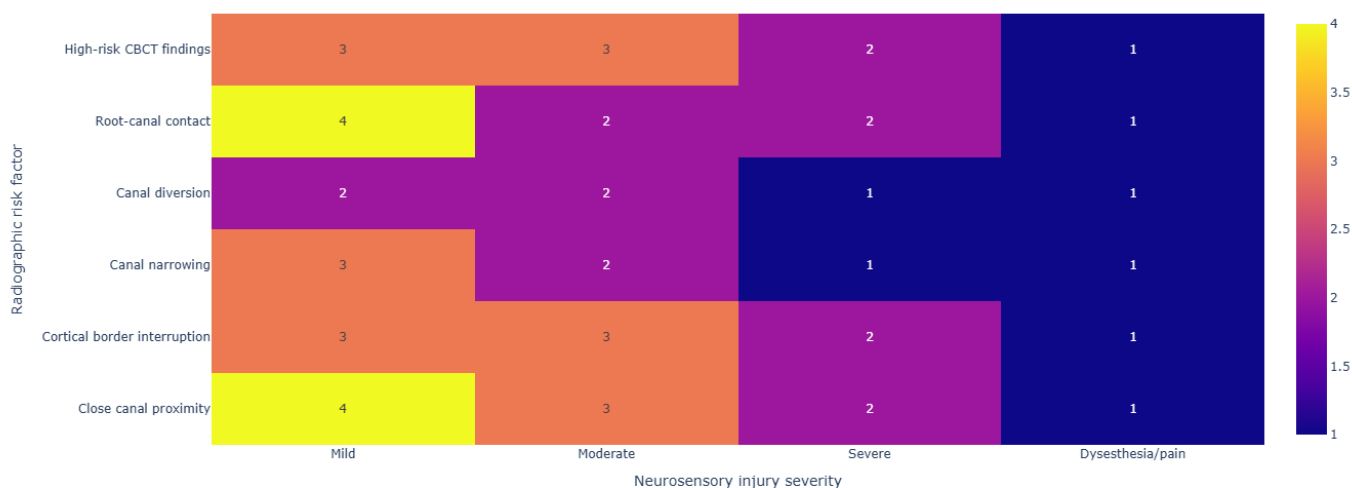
Radiographic risk factors and nerve injury severity
